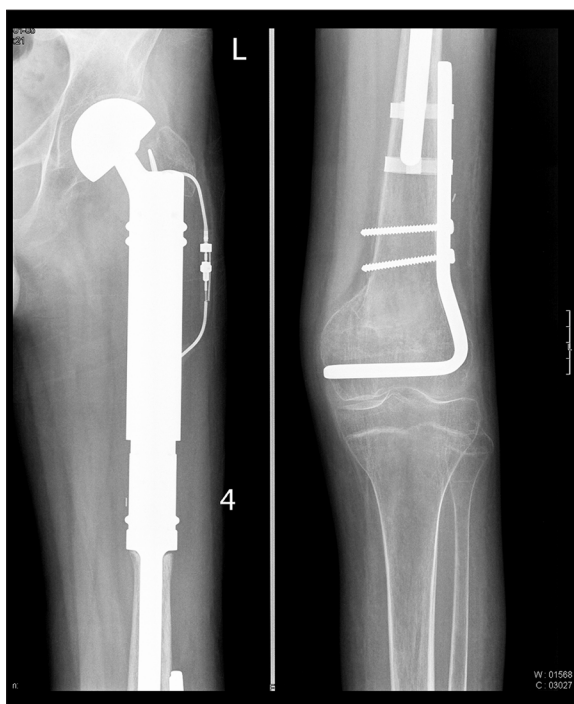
16-year-old boy with Ewing's sarcoma one year after implantation of hip endoprosthesis. X-ray: osteolytic area in the medial femoral condyle. Disease recurrence was diagnosed.
